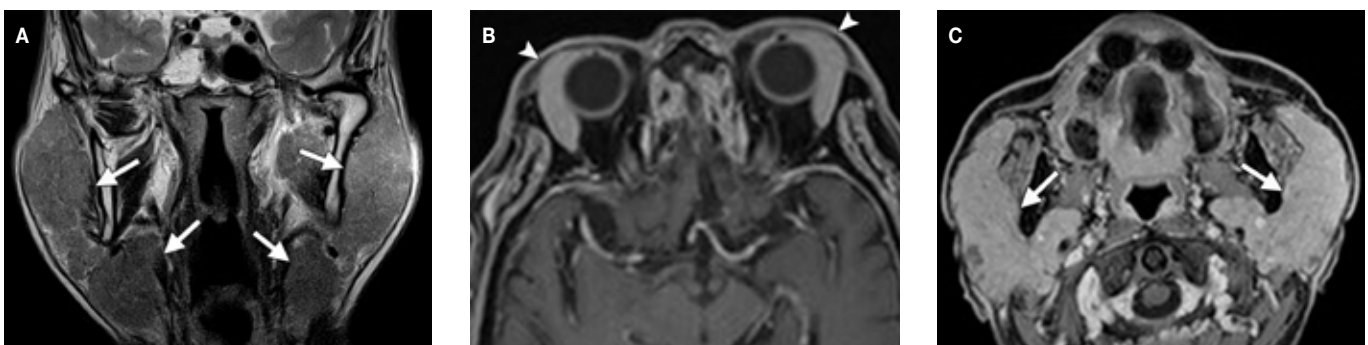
Mikulicz disease:(A) Coronal T2-weighted MR image demonstrates hypointense bilateral swelling of the parotid and submandibular glands (arrows). (B,C) Axial contrast-enhanced fat-suppressed T1-weighted MR images show diffuse homogeneous enhancement of the lacrimal (arrowheads in B) and parotid glands (arrows in C).
